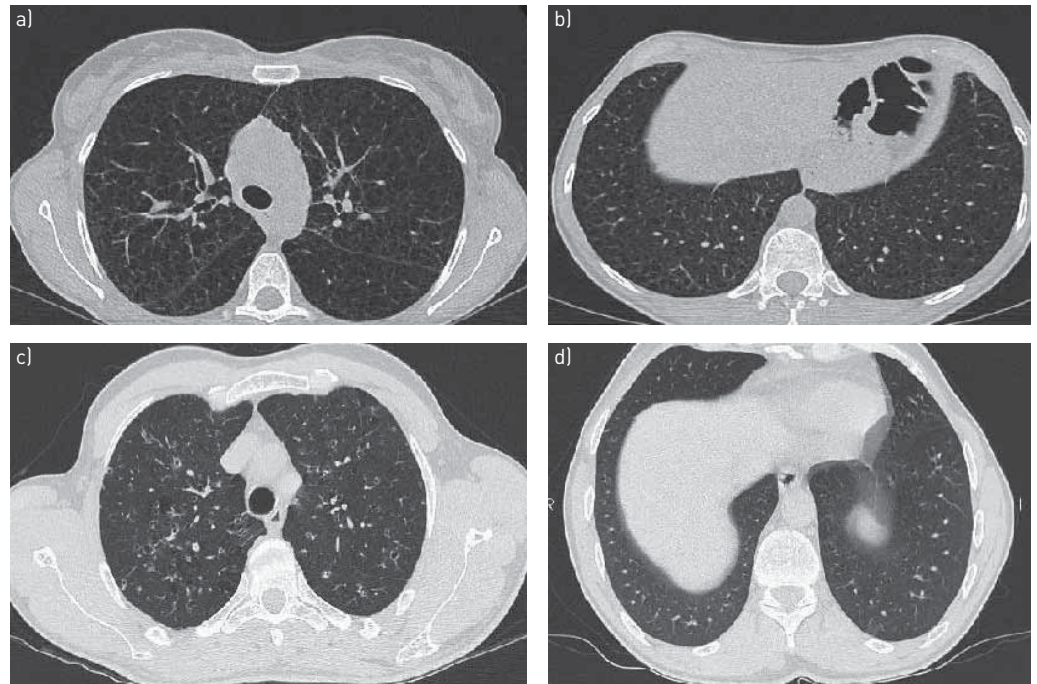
High-resolution chest computed tomography images of a patient with lymphangioleiomyomatosis, showing round-shaped, thin-walled cysts distributed diffusely throughout the lungs without sparing of lung bases (a, b), and a patient with pulmonary Langerhans cell histiocytosis with evidence of micronodules and cystic lesions mainly involving middle and upper lung fields (c, d).
